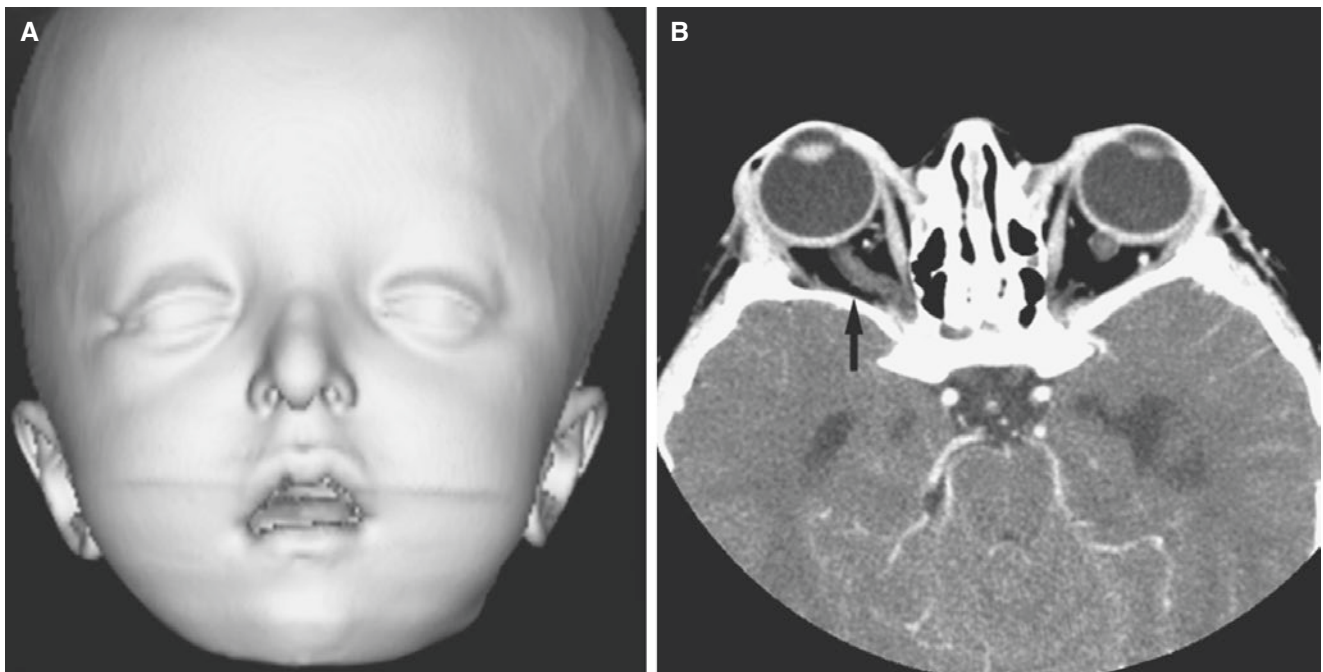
Crouzon syndrome; 3-year-old. (A) 3D CT image of the skin, en face view, shows hypertelorism, exorbitism, and open down-turned mouth. (B) Axial CT image, soft tissue, shows shallow orbits
